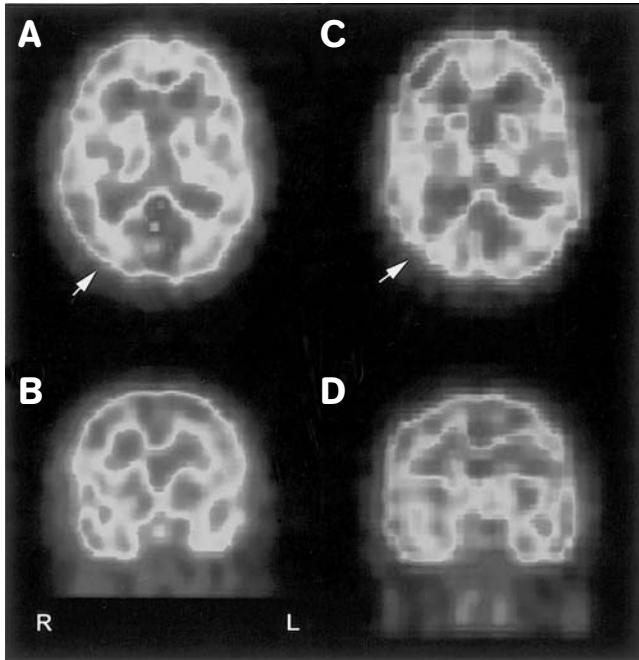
Images of SPECT taken just after the symptoms subsided (A and B) and four months later (C and D). The hypoperfusion of right occipital area (pointed by an arrow) in the acute stage was more prominent in 4 months later.
